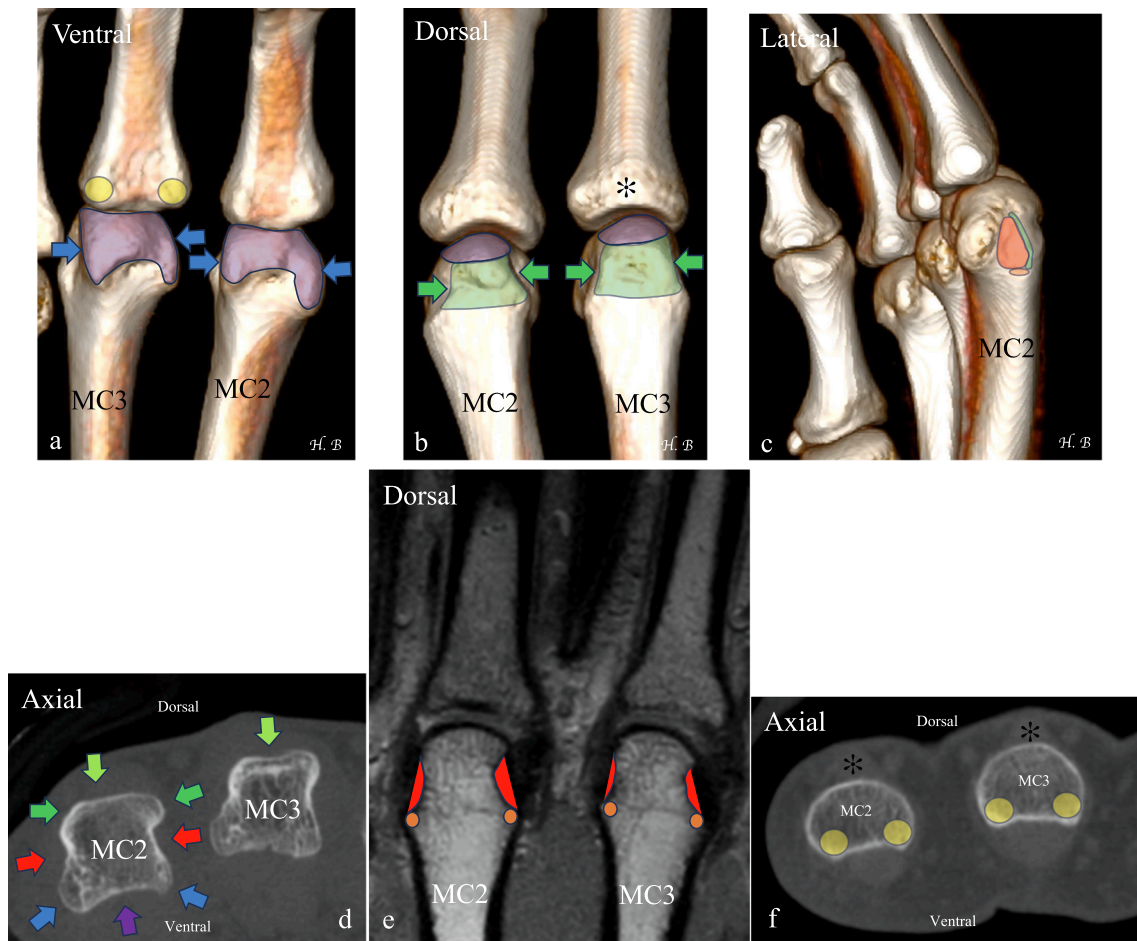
Bony anatomy of the MCPJ of the long fingers (a–f). CBCT volume-rendered reconstructions (a, b, c), axial CBCT images (d, f), coronal T1-weighted MRI (e). Bony anatomy of the metacarpal head (a–e): The volar aspect of the metacarpal head is spherical and covered with cartilage (a, purple - palmar side). The dorsal aspect shows cartilage only on its upper portion (b, purple - dorsal side). The posterior surface is articular but noncartilaginous (b, green), flat or slightly concave where the extensor tendon passes. The volar side is bordered by two prominent, mildly convex and blunt bony ridges (a, blue arrows), while the dorsal border presents two sharper, more prominent lateral crests that are slightly concave outward (b, green arrows) and end in an inferior pointed tip (b). On the medial and lateral sides, a small fossa (c, red) is located anterior to the posterior crest (c, green) and ends inferiorly in a tubercle (c, orange); the collateral ligament inserts onto both the fossa and the tubercle. The metacarpal head is asymmetrical, with the articular surface being more extensive on the radial side than on the ulnar side. On the axial CBCT view (d), the anterior borders (blue arrows) are blunt, while the posterior borders (dark green arrows) are sharp. The anterior articular surface (purple arrow) is convex; the posterior surface (light green arrows) is flat or slightly concave. The two lateral fossae are visible (red arrows). Metacarpal head anatomy on MRI (e): MRI section through the center of the metacarpal head shows the lateral fossa (red) and tubercle (orange), with the collateral ligament inserting at both points. Bony anatomy of the base of the proximal phalanx (P1) (a, b, c, f): The base of P1 has a parallelepiped shape with a concave articular surface forming the glenoid cavity. The volar surface is concave to accommodate the flexor tendons (a). On this volar surface, there are two bony protrusions where the volar plate inserts (yellow, a). The dorsal surface is smooth and convex (asterisk, b). In (f), the same features are seen: a smooth, convex dorsal surface (asterisk), a volar surface with two bony prominences (yellow) where the volar plate inserts, and a concavity for the flexor tendons.
